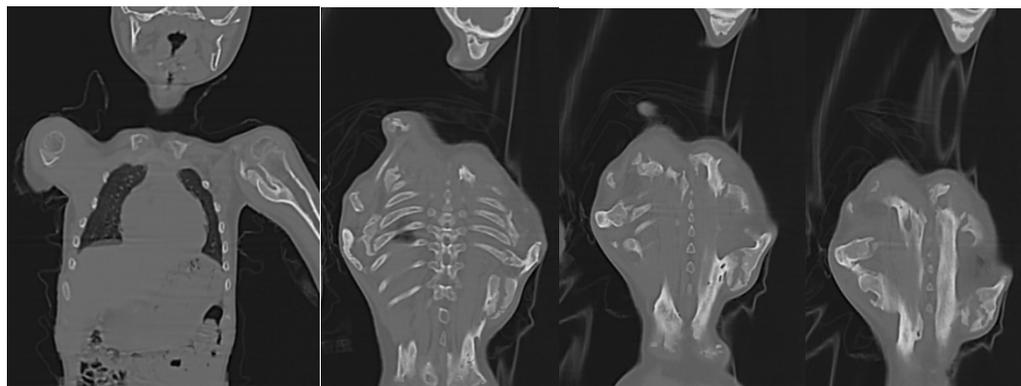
Neck CT scan shows extra skeletal ossification seen at right side of neck seen bridging between the skull base and right scapula in the same case 1 year later at 6 years of age.
